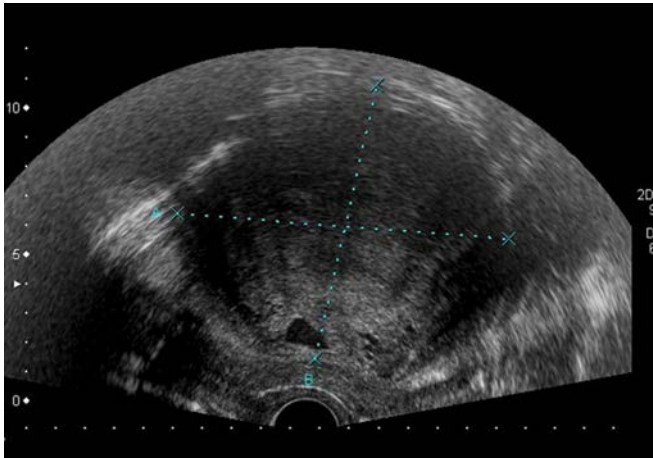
Transvaginal ultrasound in a case of endometrial stromal sarcoma. Acoustic shadowing can be observed. (Courtesy of Dr. M.A. Pascual, Institute University Dexeus, Barcelona, Spain.)
